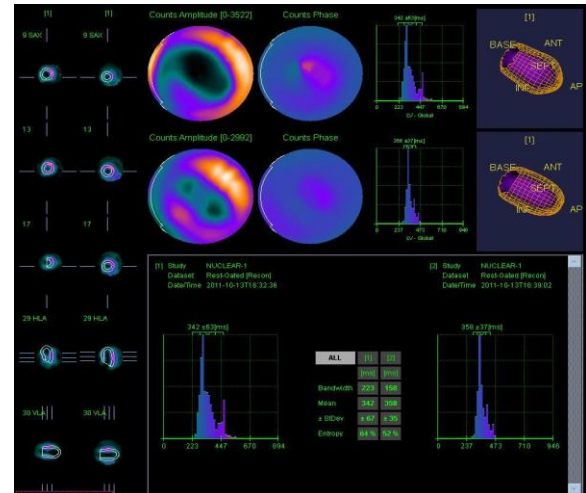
Left ventricular Gated SPECT phase analysis of patient, presenting with anterior STEMI. His phase analysis show marked decrease in count amplitudes affecting mainly apex, the anterior wall and septum. First set of images showed histogram BW: 223.0 ms (84.8°) and histogram SD: 67.0 ms (25.5°). Second set of images showed histogram BW: 158.0 ms (60.1°) and histogram SD: 35.0 ms (13.3°). R-R 946 ms (360°). Anterior STEMI data showed increased dispersion of dyssynchrony parameters, denoting dyssynchronous LV contractions. This improved partially in the coming days, following primary PCI.
